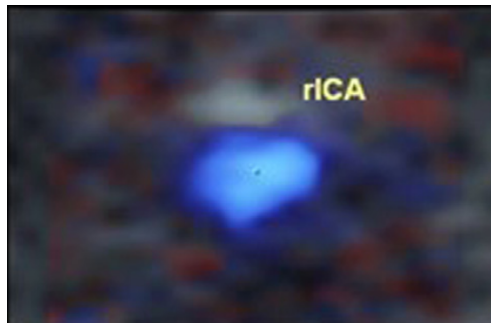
Color Doppler image of a cerebral artery, taken from Rubin *et al.*'s article [10]. The major artery shows up as blue, since the blood inside is moving away from the observing probe.
